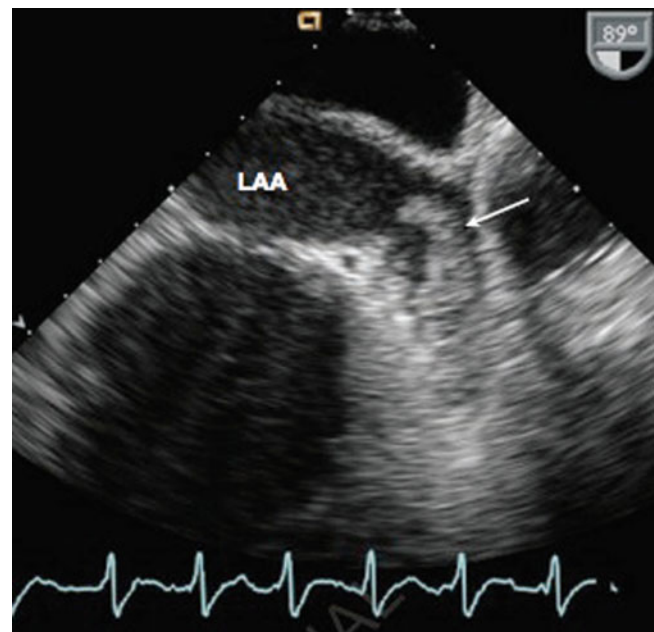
Transesophageal echocardiogram showing left atrial thrombus (*arrow*) in the atrial appendage. This thrombus was visualized in two orthogonal views, using zoom mode and a high-frequency (7 MHz) transducer (Reprinted with Permission Otto [30])
